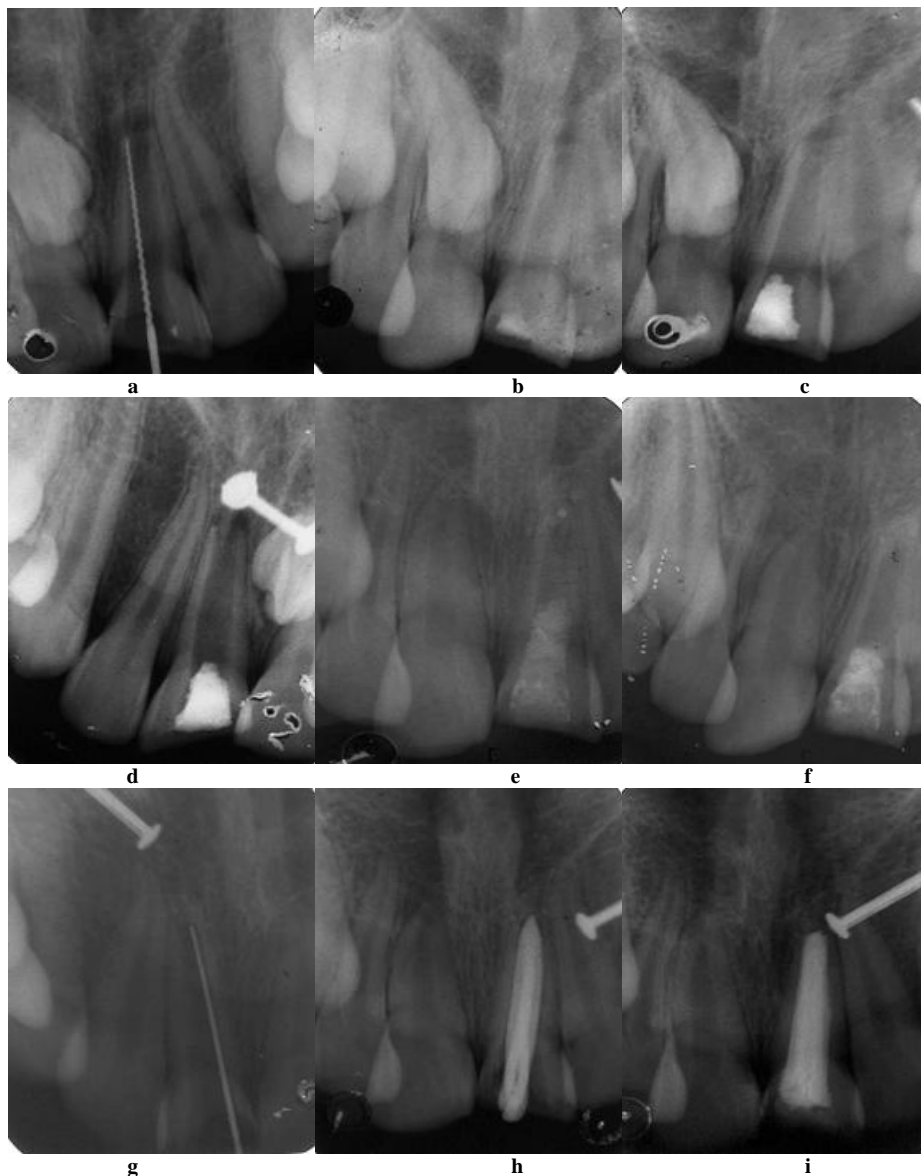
Apexification in 21 completed within 8 months: (a) access cavity prepared and working length determined; (b) calcium hydroxide paste placed in the canal; (c) access cavity restored with glass ionomer cement; (d) radiograph after 1 month shows dissolution of calcium hydroxide paste; (e) & (f) renewal of paste done; (g) radiograph after 8 months shows hard tissue bridge in the apical region; (h) & (i) obturation done with Gutt-percha.
